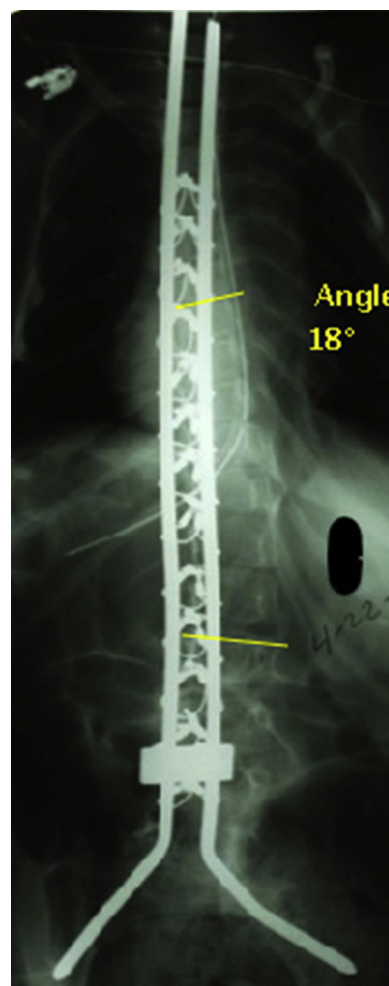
Child #1 – Intraoperative PA Radiograph, yellow lines represent Cobb angle. Surgimap Spine Software (Nemeric Inc, 306 E 15th Street, New York, NY 10003).
